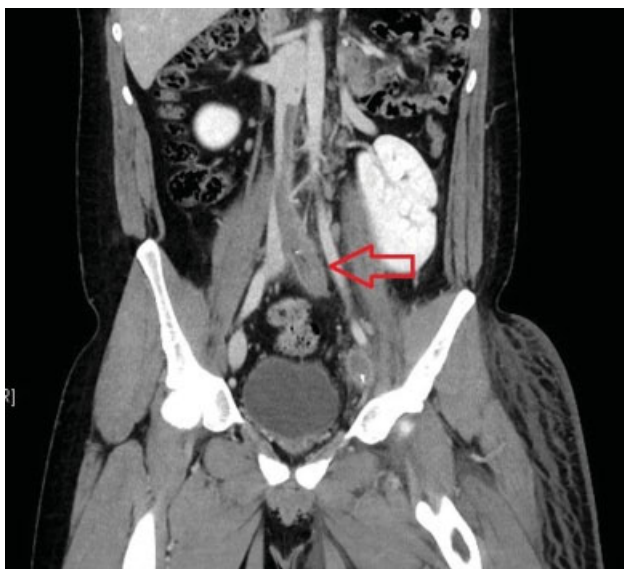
Computed tomography angiography of the abdomen and lower extremity: occlusive venous thrombosis of the left common femoral and iliac veins extending to the lower caval vein.
